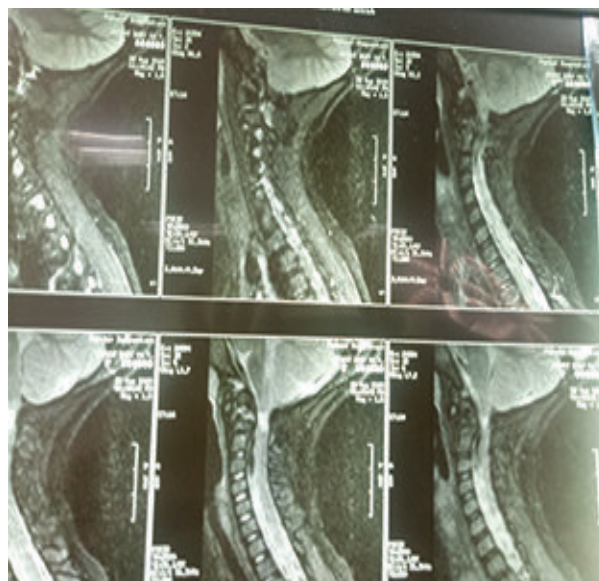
MRI of cervical spine showed atlantoaxial dislocation with cord compression
